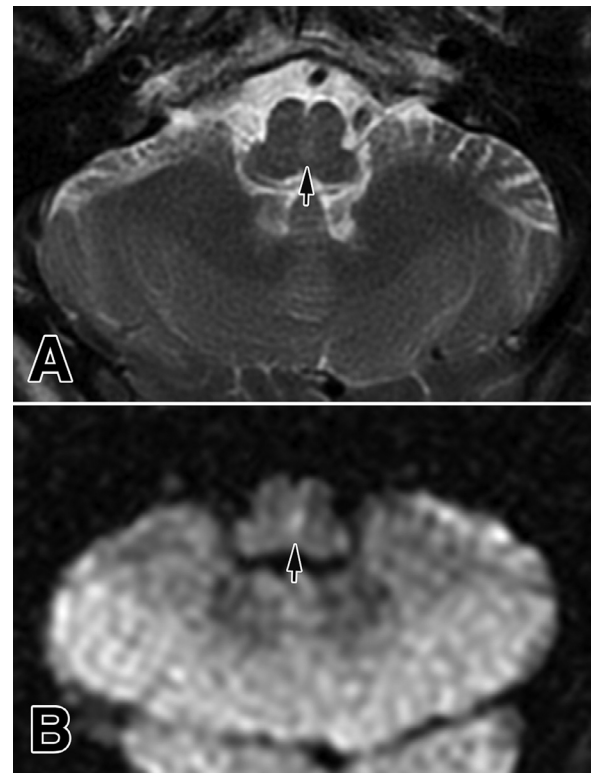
A partial medial infarction of the upper medulla, affecting mainly the centromedial area (arrows) in the axial T2-weighted (A) and a DWI image (B). The MRI was performed 5 days after onset.
